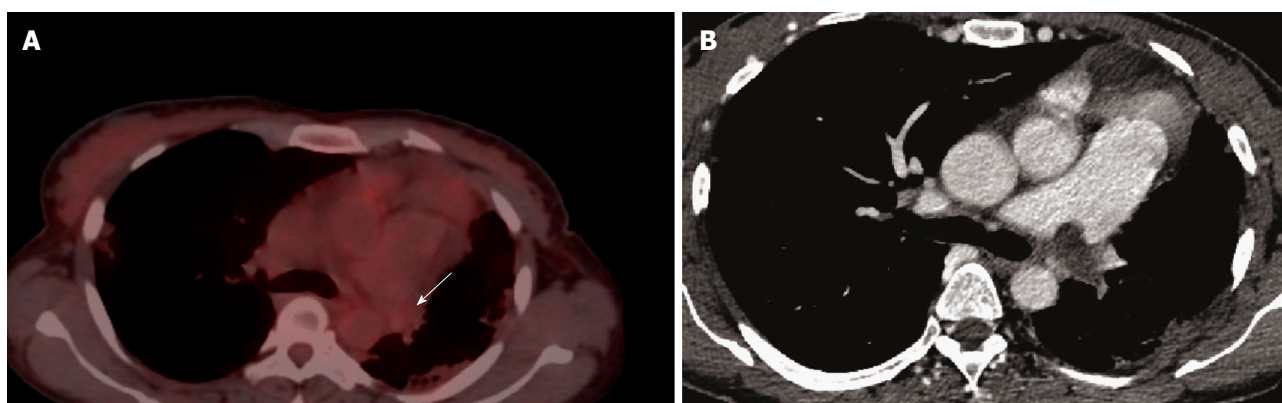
Differtiation between tumoral thrombus from bland thrombus. A: Differtiation between tumoral thrombus from bland thrombus in female patient with history ovarian cancer, patient was known to have chronic pulmonary embolism, there was a bland thrombus almost occluding the left pulmonary artery was no FDG uptake (arrow); B: Axial CT image shows a left pulmonary artery thrombus. CT: Computed tomography; FDG: Fluorodeoxyglucose.
